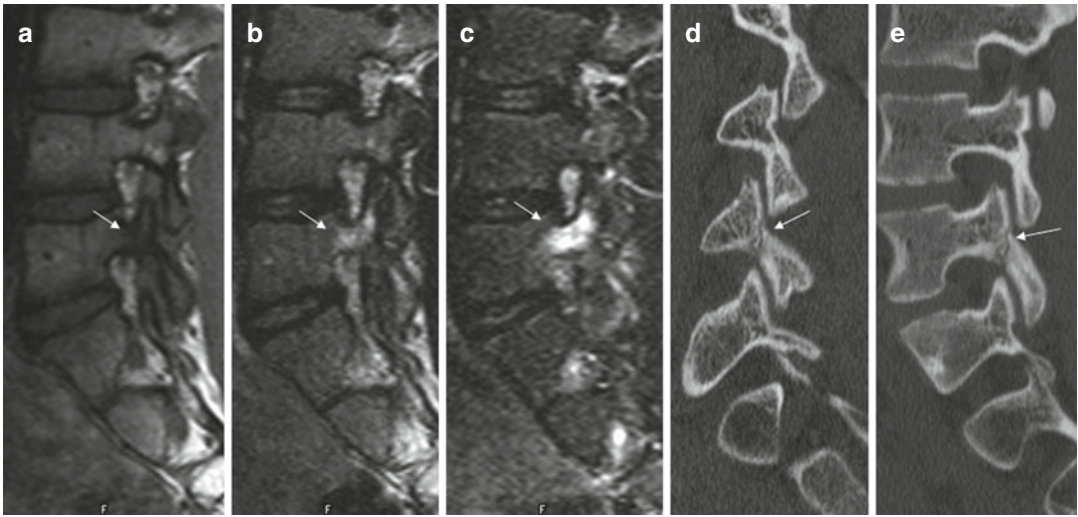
Pars fracture and pedicle hyperintensity: (a) parasagittal T1-, (b) T2-, and (c) STIR-weighted images of the lumbar spine (d, e) are oblique and sagittal multiplanar reformatted (MPR) CT images (respectively) of the lumbar spine. Note the decreased signal intensity on T1 (→ Fig. 10.4a) and increased signal intensity on T2- and STIR-weighted images (→ Fig. 10.4b, c) within the pedicle of the L4 vertebral body on the *right*. A subtle pars fracture is demonstrated on the oblique (d) and sagittal (e) MPR CT images (→)
